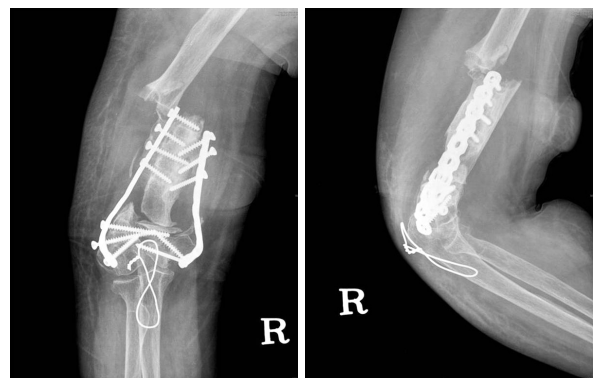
Two years later, radiographs show the bone resorption of grafted bone and newly developed fracture near proximal portion of the plate.
